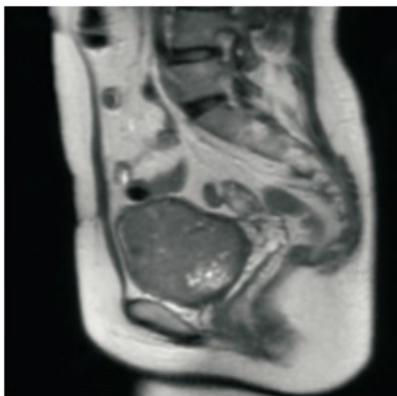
Pelvic MRI: Soft tissue mass in anterior subuterine view, uneven signal, unclear boundary of bladder compression, no enlarged lymph nodes in pelvic cavity, and no abnormality in pelvic wall structure.
